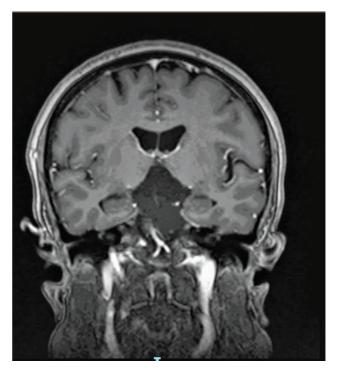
Enterogenous cyst: MRI showing a cystic lesion measuring $4.6 \times 3.6 \times 3.5$ cm and arising in inferior wall of the third ventricle.
